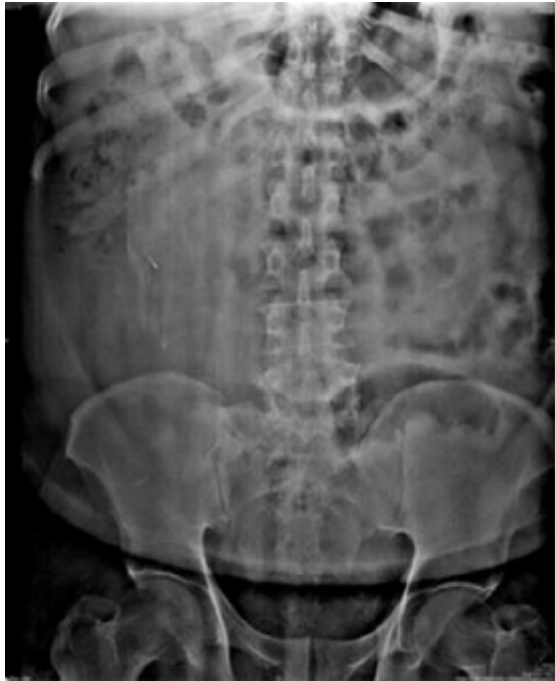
Lumbosacral AP Radiographs: showing dysplastic and enlarged transverse process of L5 vertebra on left side (A)-type IA and bilaterally (B)-type IB.
